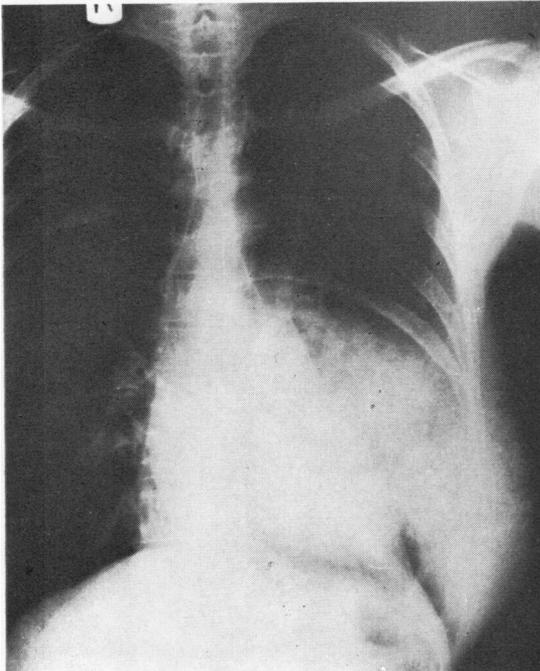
Case 3. Preoperative anteroposterior radiograph showing extent of rib destruction from the chondrosarcoma involving the left lateral and posterior chest wall.
